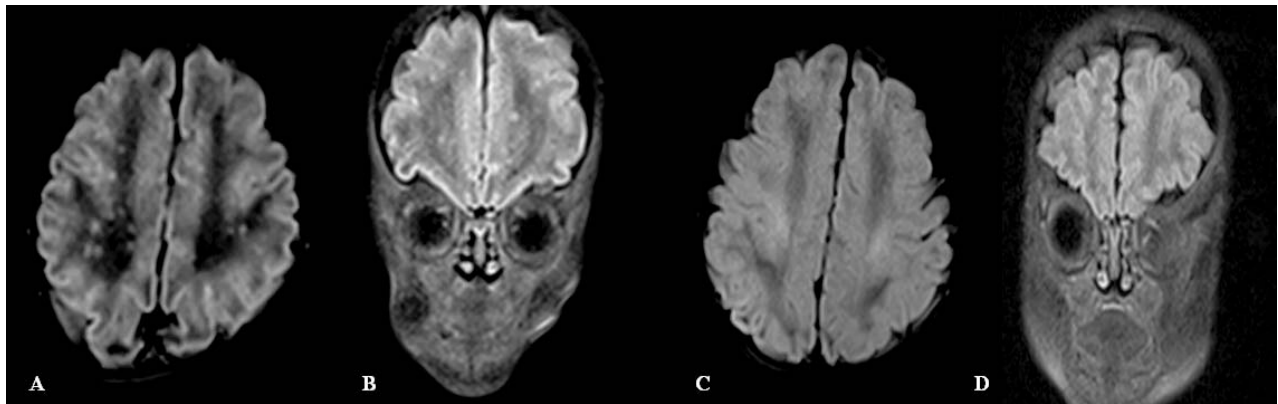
Fungal cerebral abscesses. Case 7: T2-weighted dark flare cerebral MRI. A, B: the multiple punctate lesions performed higher signal in bilateral frontal, temporal, occipital, and parietal lobes. C, D: one month later, the multiple punctate higher signal lesions disappeared.
